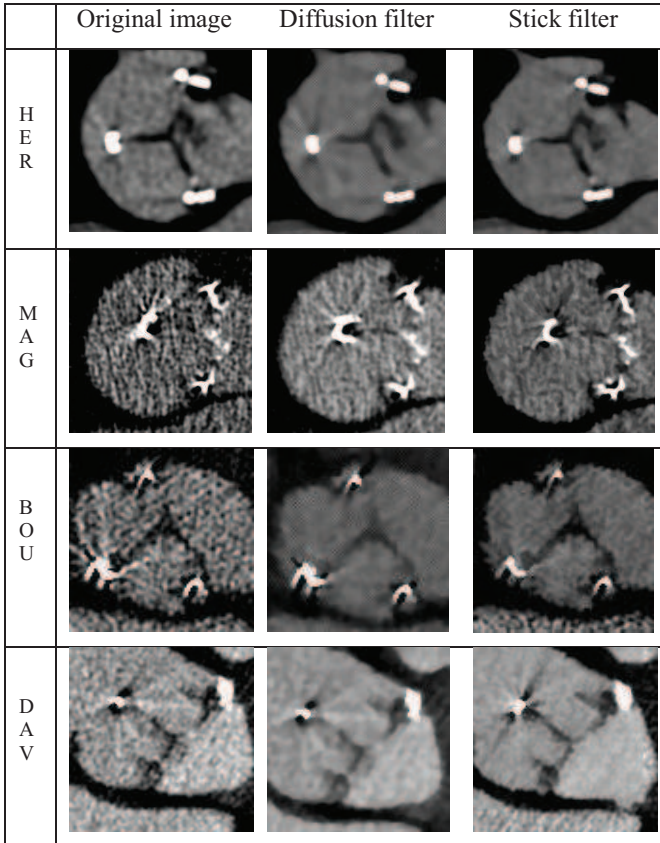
Results of CT images preprocessing by Diffusion and Stick filters.
